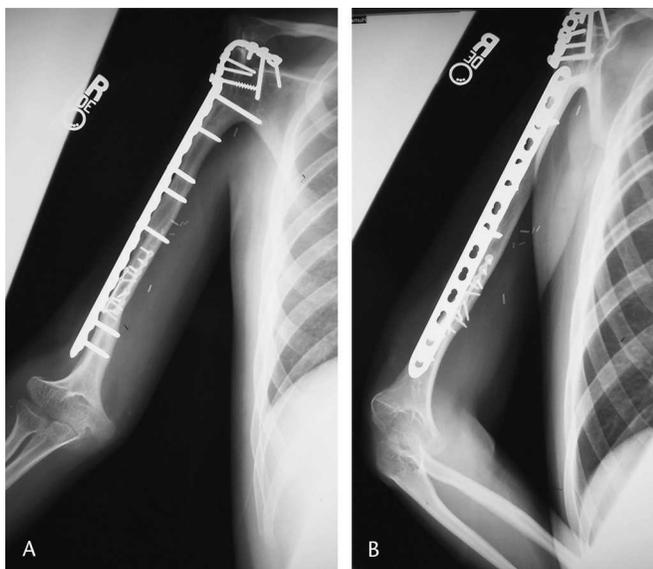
(A) Anteroposterior and (B) lateral radiographs show the right humerus at 3 years followup.
